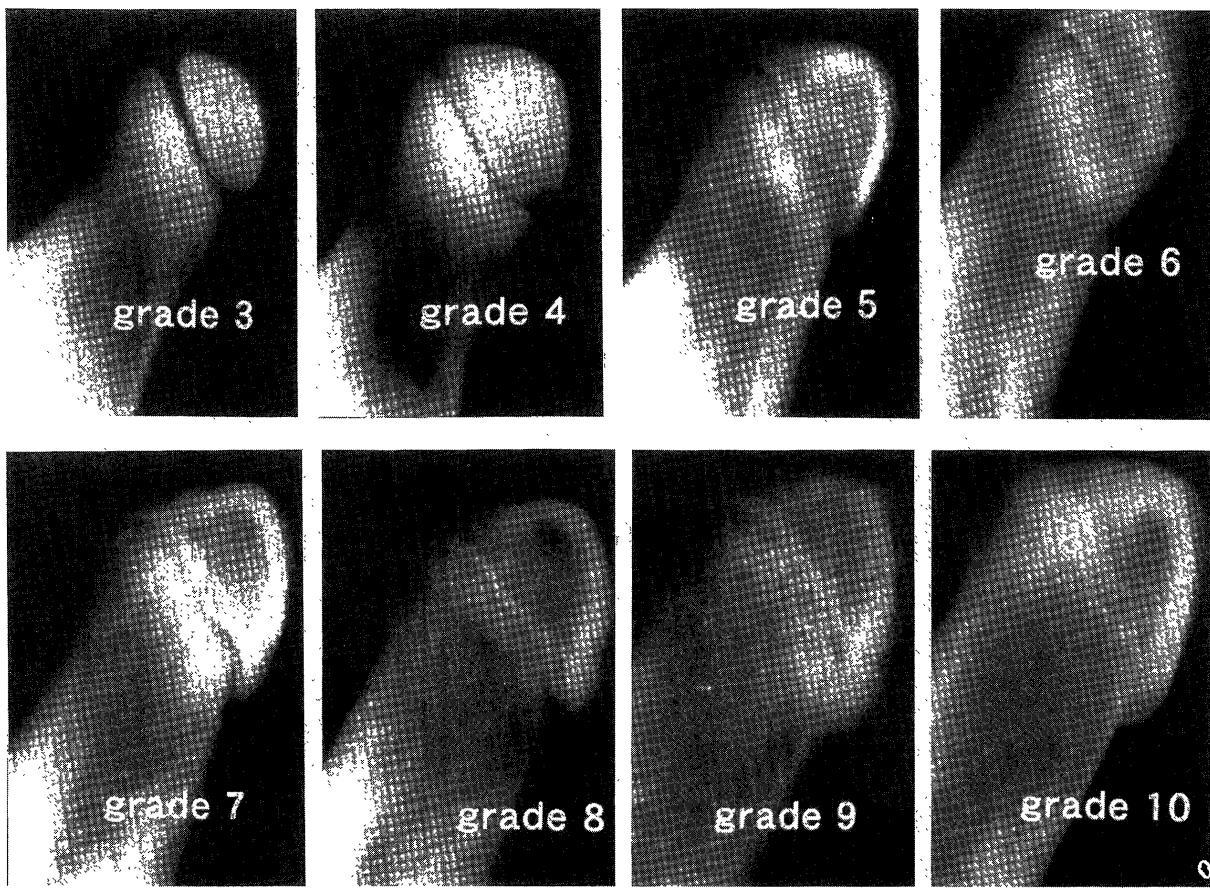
Radiographs of standard ossification in the tuber calcaneus. Immediately after birth, the ossification stage was grade 3 or 4. Grades 5, 6, 7, 8, 9 and 10 were found at 1–2, 3–4, 5–6, 7–8, 9–25 and 26–29 months of age, respectively.
